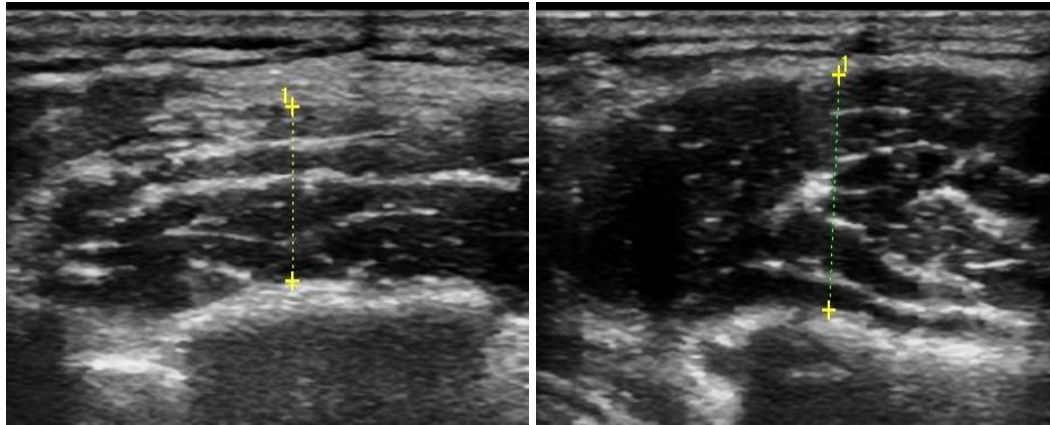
(Right, Left): Ultrasonographic examination showing increased thickness of the left masseter muscle (1.16cm) when compared to right side (0.88cm)
